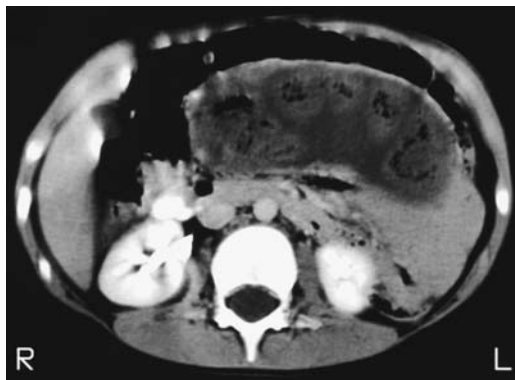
Small bowel intussusception in an 8-year-old boy with Peutz-Jeghers syndrome. The greatly dilated small bowel loop contains several nondilated loops in this CT image, reflecting the chronicity of this condition. (Courtesy of Patrick Fultz, M.D., University of Rochester.)
